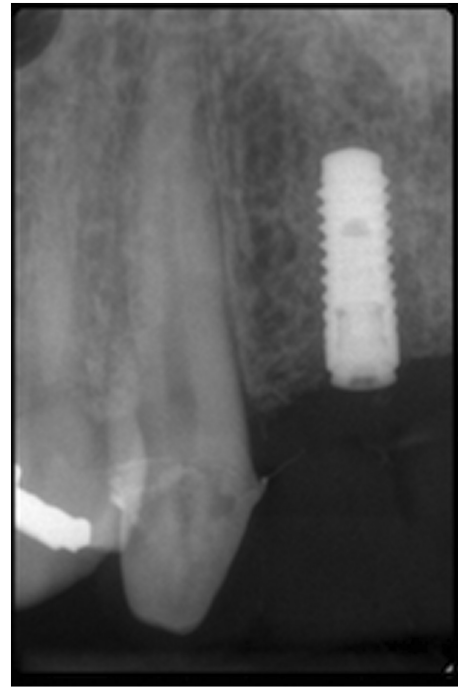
Periapical radiograph showing implant # 12.
